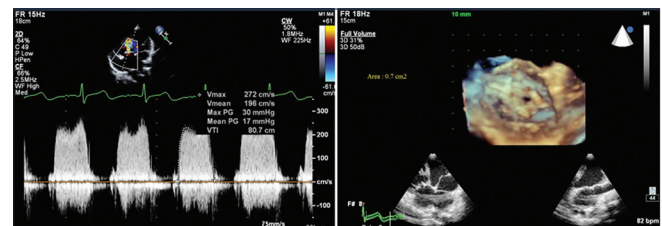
Echocardiography highlighting the severity of stenosis: Continuous wave Doppler across the systemic atrioventricular valve highlighting severe stenosis (peak gradient of 30 mmHg and mean gradient of 17mmHg). Valve area is 0.7 cm² on three-dimensional echocardiography, with fused commissures
